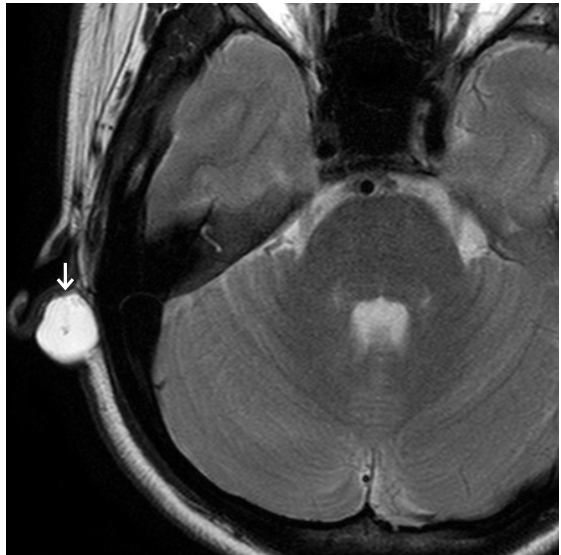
Axial T2W MRI of right parotid region shows a well circumscribed cystic lesion (→) at the right post-auricular region. No definite sinus tract communicating with the skin or external auditory canal was demonstrated. The location is classical for a 1st branchial cleft cyst.
